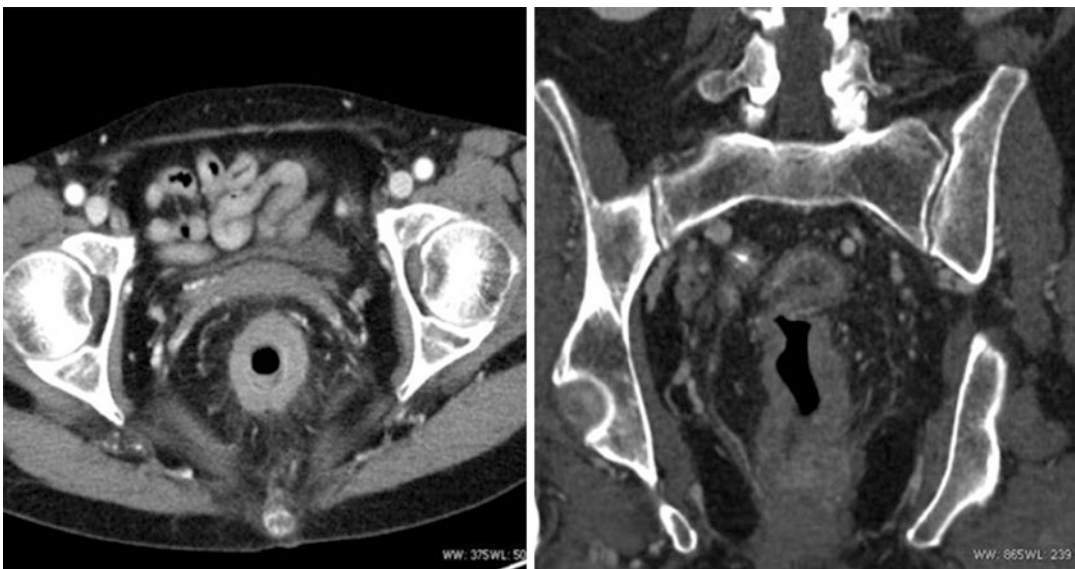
Computed tomography image demonstrating locally advanced rectal cancer. (With permission © Springer)
